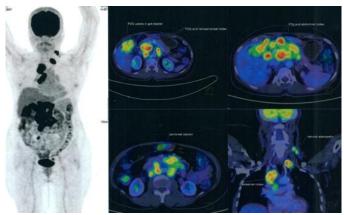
Abnormal areas of FDG uptake in level V SUV 12.59, Left supraclavicular lymph node SUV 14.24, Right upper Para tracheal lymph node SUV 14.98, Carinal lymph node SUV 14.74, Right hilar node SUV 15.24, Gall bladder SUV 11.83, Portocaval SUV 15.95, Peripancreatic SUV 16.30, Periportal SUV 16.62, Aortocaval
